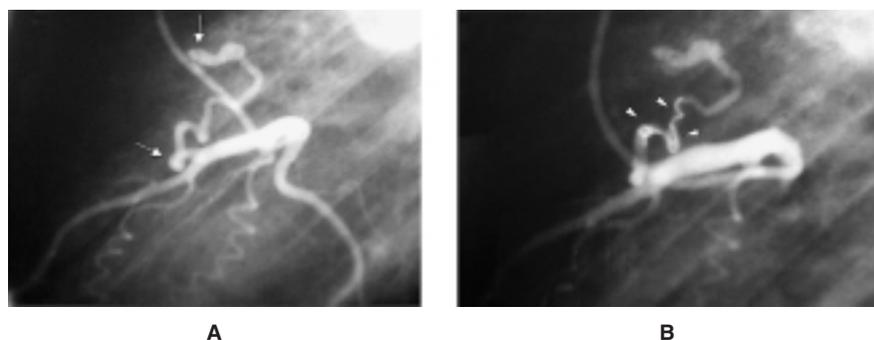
Left lateral angiographic incidence of the left coronary artery showing a single fistulous vessel emerging from the left anterior descending coronary artery and draining into the pulmonary artery (white arrows) in a 65-year-old woman presenting with medium threshold exercise angina and scintigraphic anterior wall reversible ischemia (A). Selective left anterior descending coronary artery contrast injections in the left lateral projection show persistent flow in the fistula after coil embolization (white triangles) (B). An exercise test and perfusion myocardial scintigraphy performed 3 months following the procedure were negative for ischemia, suggesting full late closure of the fistula by coil-induced thrombosis.
